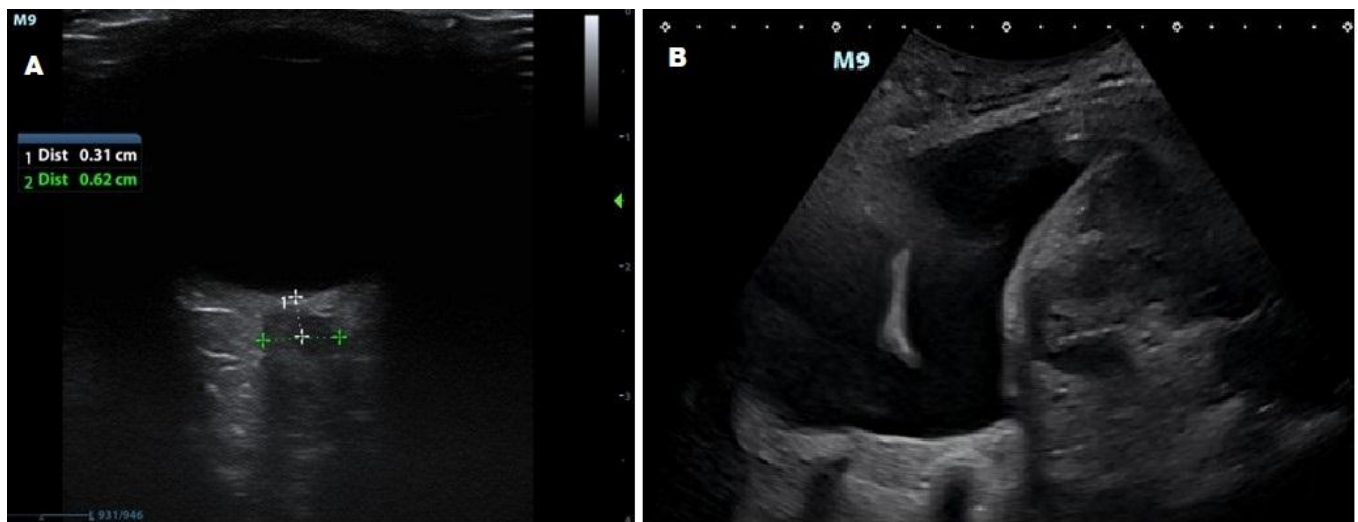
(A) Transverse orbital ultrasound image shows the optic nerve sheath at 6.2 mm, 3 mm behind the globe, (B) A lung ultrasound image displays lung collapse and pleural effusion indicating severe fluid retention.
